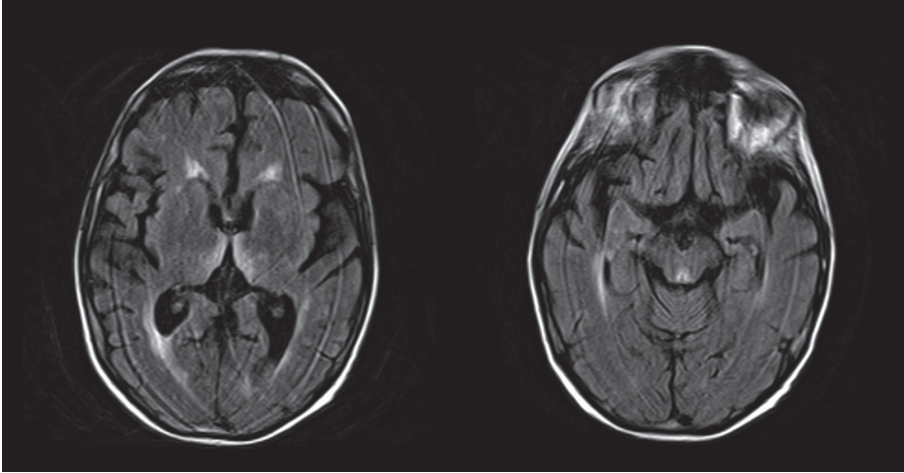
Axial MRI FLAIR showing hyperintense signals (white) in the mesial dorsal thalami (left) and periaqueductal gray matter and tectum (right). Both are common findings in untreated Wernicke's Encephalopathy and are at least in part recoverable by acute parenteral thiamine treatment. Reproduced under Creative Commons Attribution.
